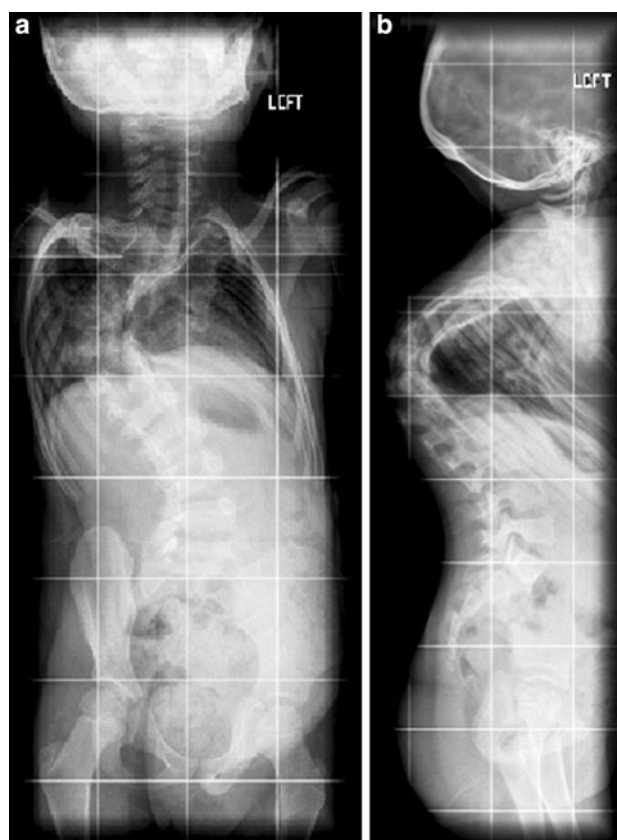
X-rays demonstrated multiple congenital rib abnormalities together with absent posterior elements
